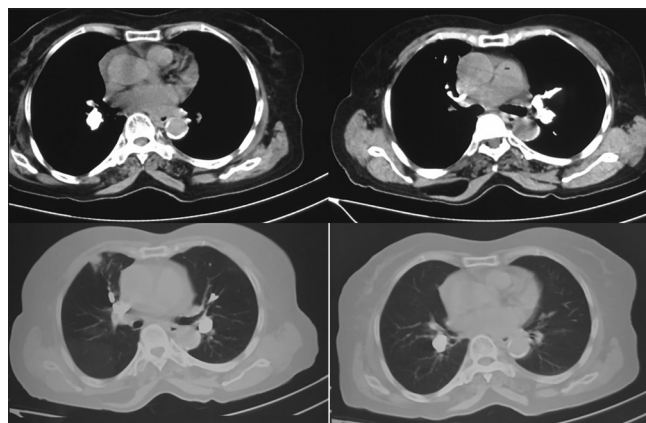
Chest CT scan: Mediastinal (top) and lung window (bottom)
